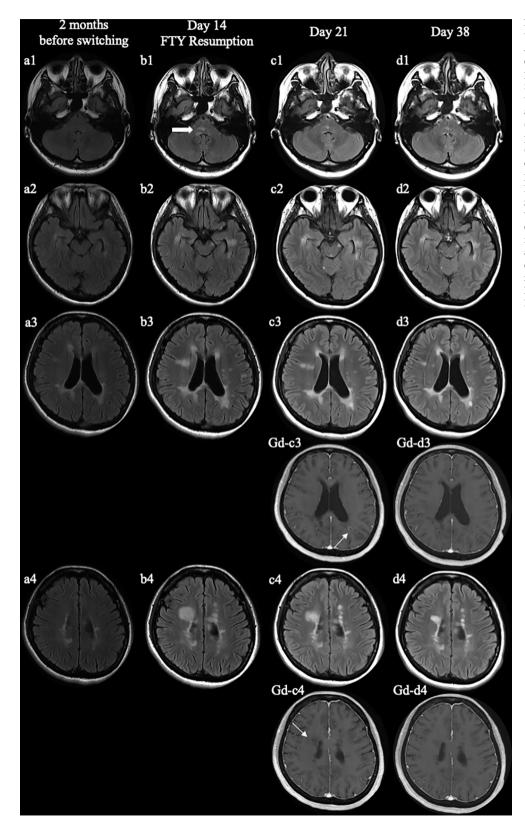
Brain MRI before and after switching treatment from fingolimod to siponimod.
